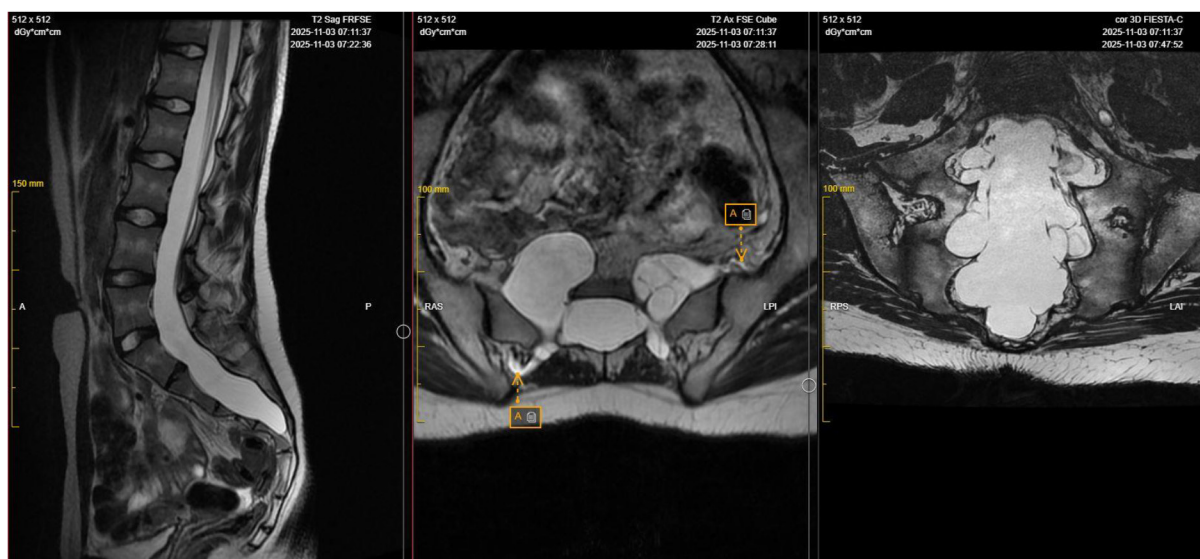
Spine MRI scan (left to right: T2-weighted sag, T2-weighted ax Cube, T2-weighted 3d Fiesta): dural ectasia with ballooning/widening of the dural sac in Th-L-S regions of the spine, multiple perineural cysts (Tarlov cysts) in the sacral region with extensions along the nerve roots distally from the sacrum (A).
